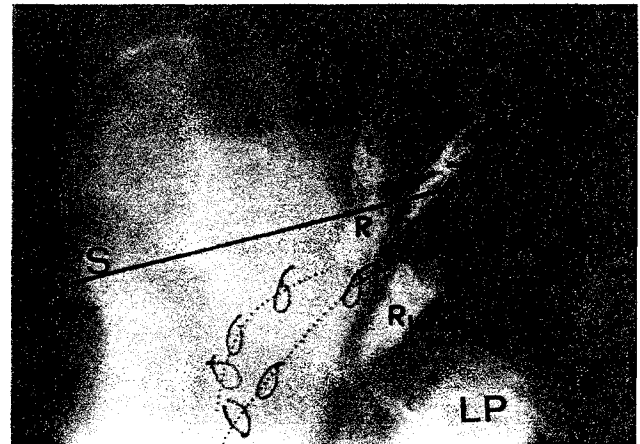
Vaginal stretching during micturition. This represents a standing lateral X-ray of an asymptomatic patient. The resting closed position film is superimposed on a micturition film. Three vascular clips have been applied to the midurethra, bladder neck and bladder base areas of the vagina (.....) in the resting position. The lower lines represent the micturition position of the vagina, levator plate (LP), angled during micturition. R, rectum in the resting position, Ru in the straining position. The black line joins the inferior border of the pubic symphysis (PS) to the lower end of the coccyx.
